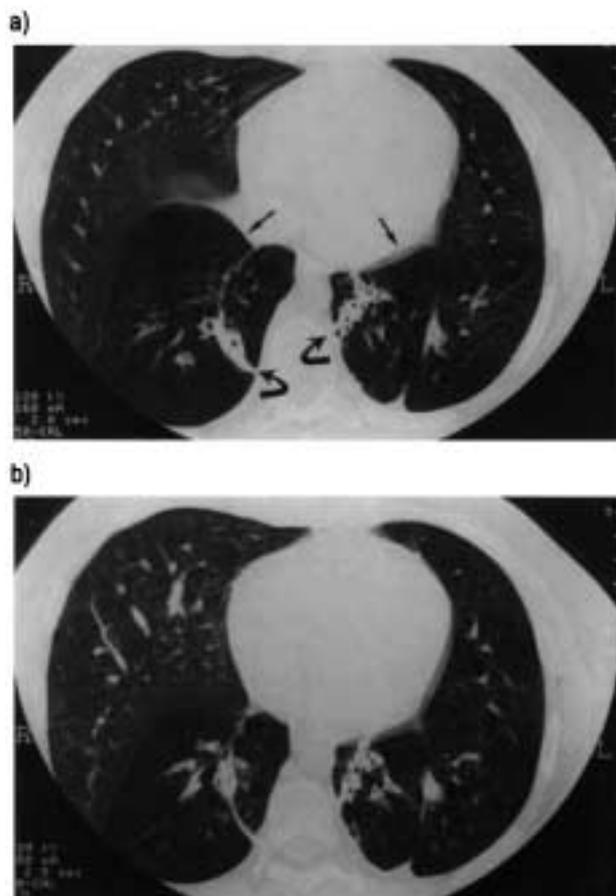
Patient No. 2. a) High-resolution computed tomography (HR-CT) scan during inspiration, showing bilateral lower lobes hyperlucency (straight arrows) with minimal cylindrical bronchiectasis (curved arrows). b) HR-CT scan during expiration, showing air-trapping in the lower lobes.
